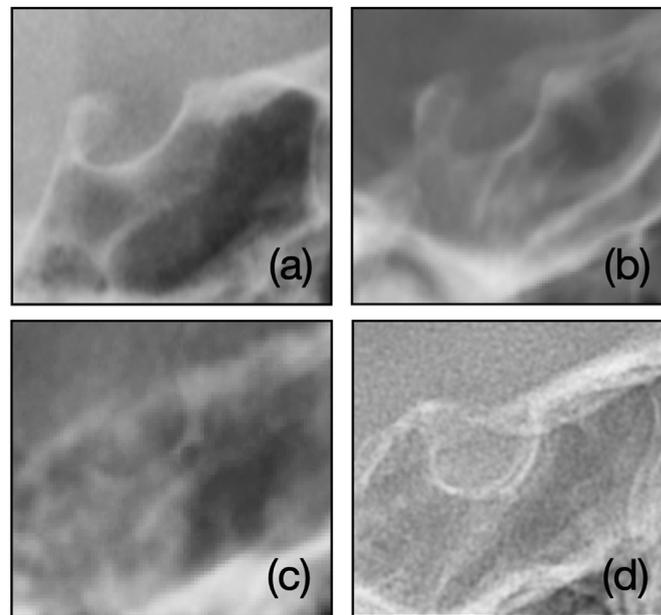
Images of the sella turcica. (a) Normal sella turcica. (b) No bridge showed on the 2D lateral cephalogram. 3D CBCT confirmed a complete STB on the right side in the same patient. (c) Complete STB showed on an image of 2D lateral cephalogram. However, there is no bridging on both sides of the sella turcica in 3D CBCT. (d) Complete bridge showed on the 2D lateral cephalogram, and complete STBs on both the left and right sides in the same patient were confirmed by 3D CBCT.
